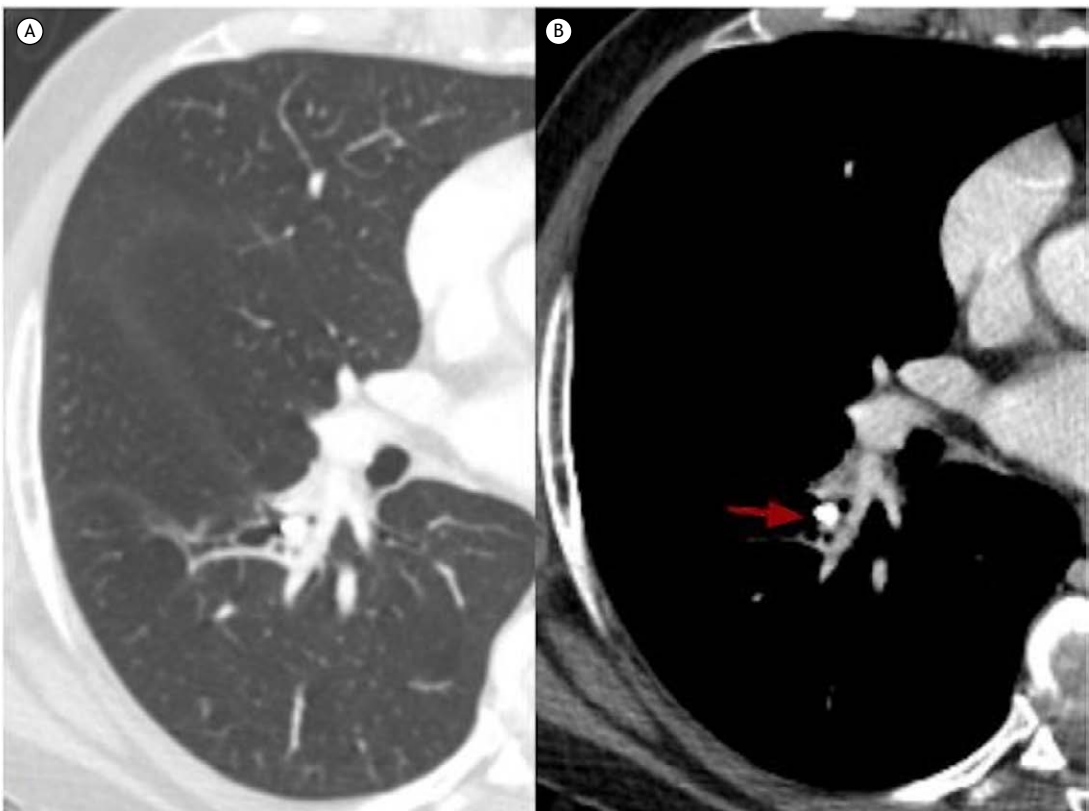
Axial CT scans with lung (A) and mediastinal window (B) settings revealing a broncholith within a segmental bronchus of the right lower pulmonary lobe (arrow).
